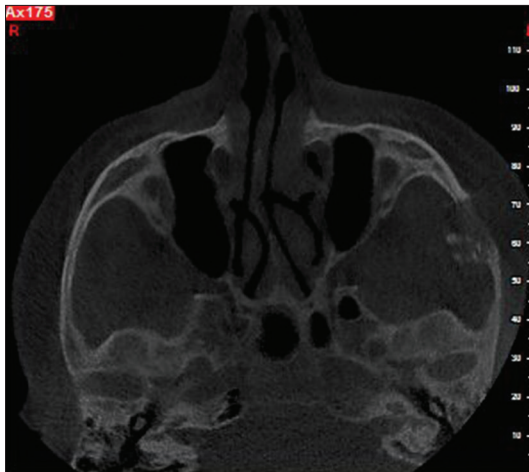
Computed tomography scan revealed a 3 × 2_{Cm} lesion in the zygomatic bone
